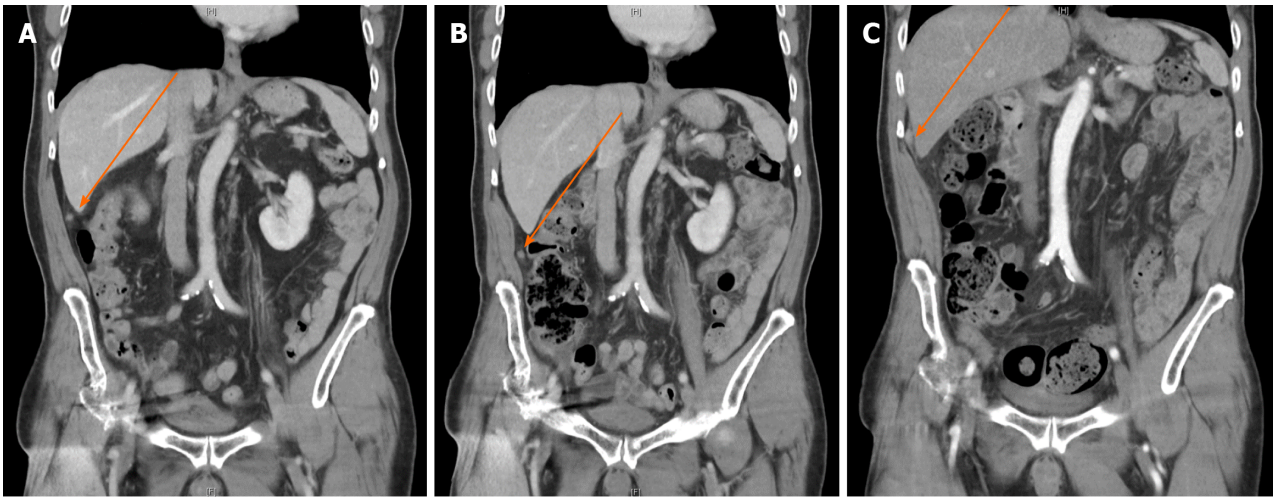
Suspected local recurrence or metastasis on abdominal computed tomography scan. A: August 2022; B: December 2022; C: March 2023.
